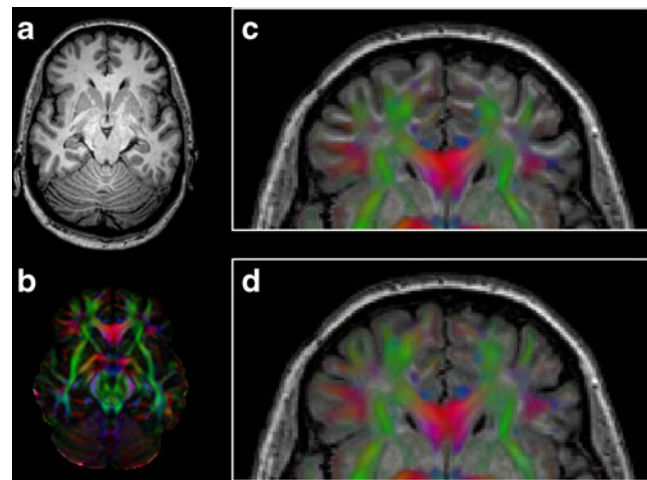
By combining an undistorted structural T1-weighted MR image (a) with the directionally encoded fractional anisotropy map of the same subject (b), one can appreciate the presence of EPI related geometric distortions from the overlay in c. The alignment between these images is clearly improved after correcting the DTI data for this artifact, as shown in d
